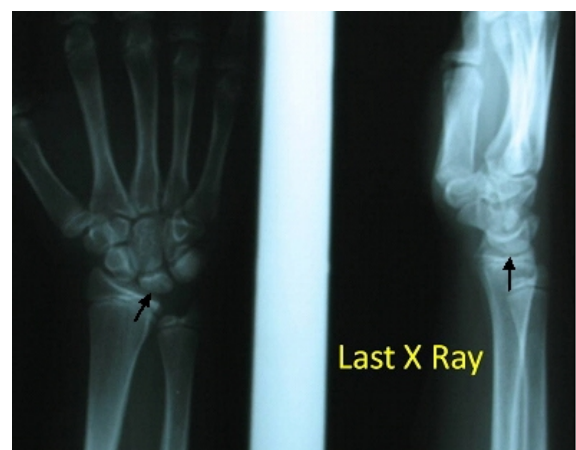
Radiographic pattern of the wrist twelve months after trauma showing the return to normality.
